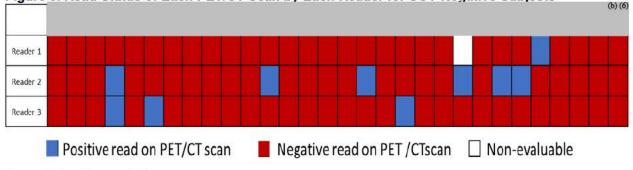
Read Status of Each PET/CT Scan by Each Reader for SOT-Negative Subjects
